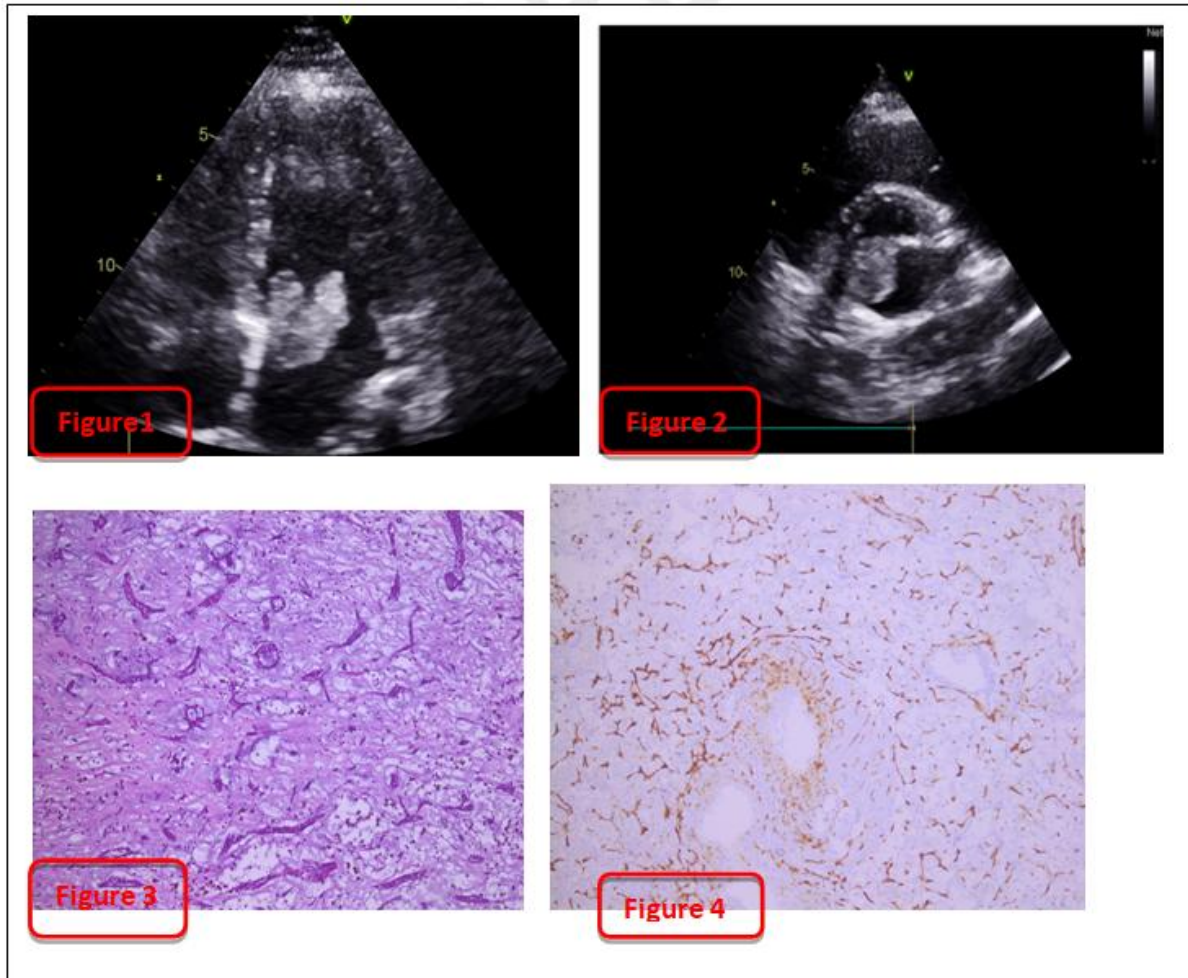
cardiac mass in apical 4 chamber view.
